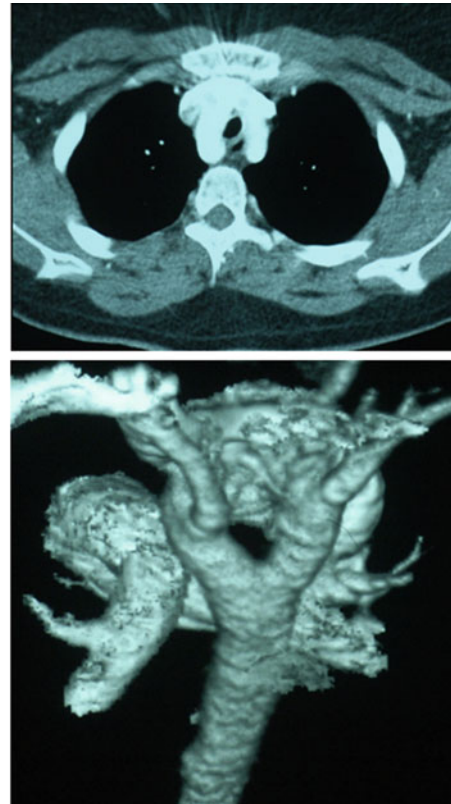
A 16-year-old girl presented with a 6-year history of wheeze. The flow-volume loop shows characteristic plateau in inspiratory and expiratory limbs, suggesting fixed airway obstruction. A thoracic CT
